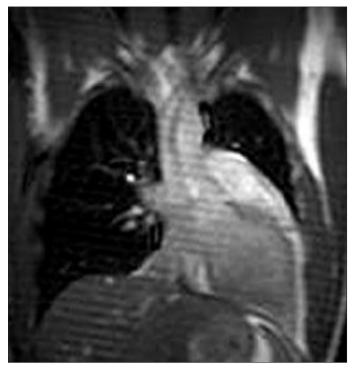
Coronal balanced turbo field echo MR image shows significant displacement of the heart into the left hemithorax with enlargement of the left atrial appendage that is consistent with the absence of pericardium.
